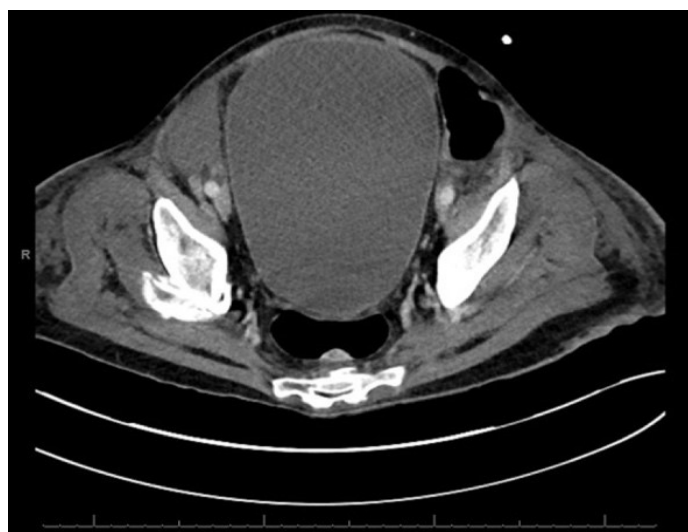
CT image demonstrating a grossly distended bladder in-keeping with a poorly inserted and non-draining catheter. The large bladder compressed the distal sigmoid colon, slowing transit.
